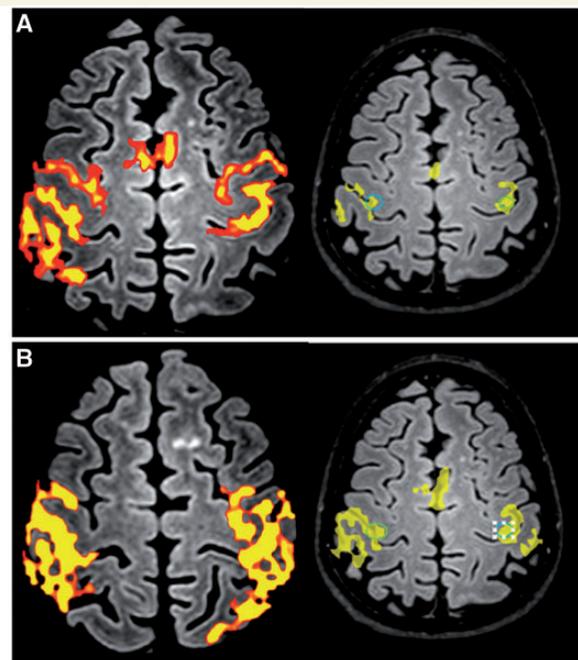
Bilateral functional MRI blood oxygen level-dependent response over precentral, post central gyrus and supplementary motor area during unimanual task. The patient was asked to perform a finger tapping task with either (A) the right hand or (B) the left hand.
